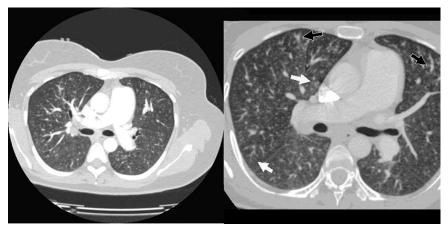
Thoracic computed tomogram with intravenous contrast reveals (A) dilatation of main pulmonary arteries by >3 cm, and (B) interstitial micronodular pattern, with dilated and beaded vessels (black arrows) and tree-in-bud pattern (white arrows).
